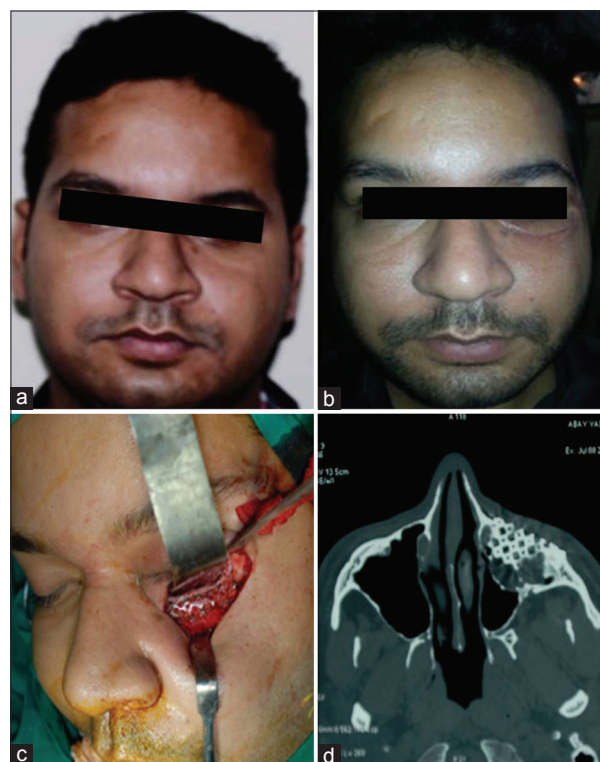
(a) Preoperative. (b) Postoperative. (c) Intraoperative use of porous high-density polyethylene. (d) Postoperative computed tomography scan
